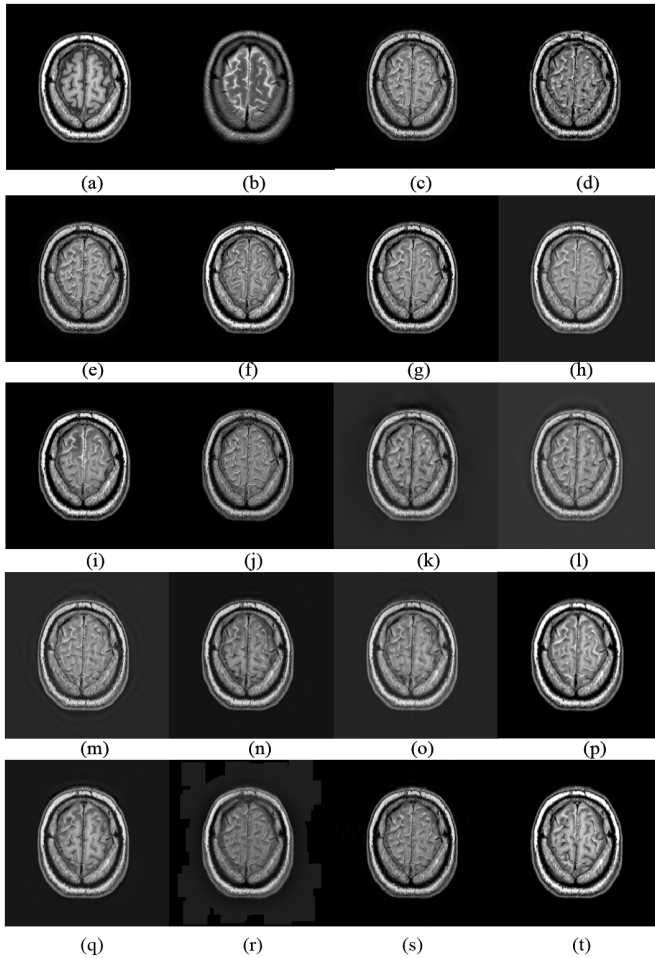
Experiments for S6. (a) CT. (b) MRI. (c) GP [52]. (d) DWT [52], [53]. (e) fsdP [52]. (f) GFS [54]. (g) CSR [55]. (h) ASR [56]. (i) GFF [57]. (j) MSVD [58]. (k) DTDWT [59]. (l) SWT [60], [61]. (m) CVT [62]. (n) DTCWT-SR [63]. (o) CVT-SR [63]. (p) LRSDL [64]. (q) PCLLE [65]. (r) MSGIF [66]. (s) DCHWT [67]. (t) Proposed.
